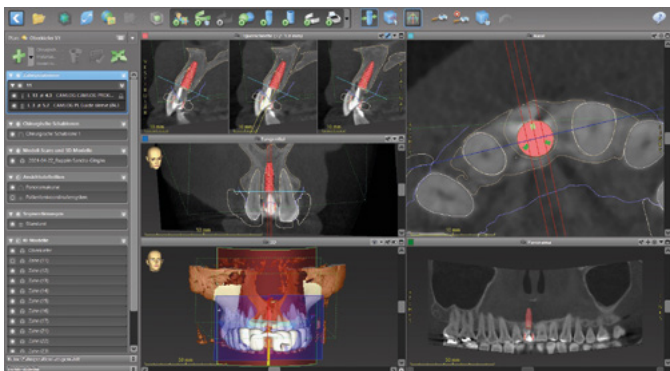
CBCT scan used for digital planning
